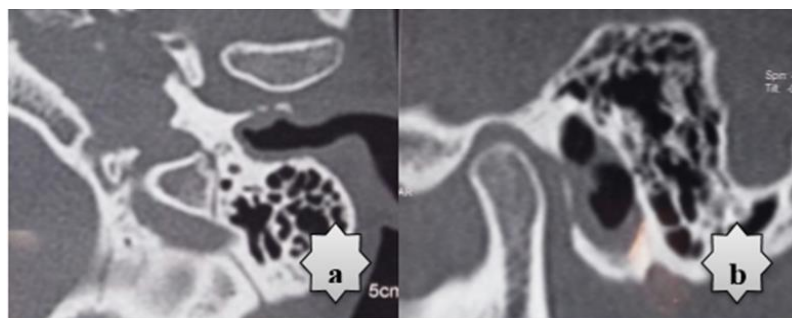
Axial (a) and coronal (b) temporal-bone CT of the left ear, showing irregular thickening of the external auditory canal walls with an eroded tympanic bone (stage I)
